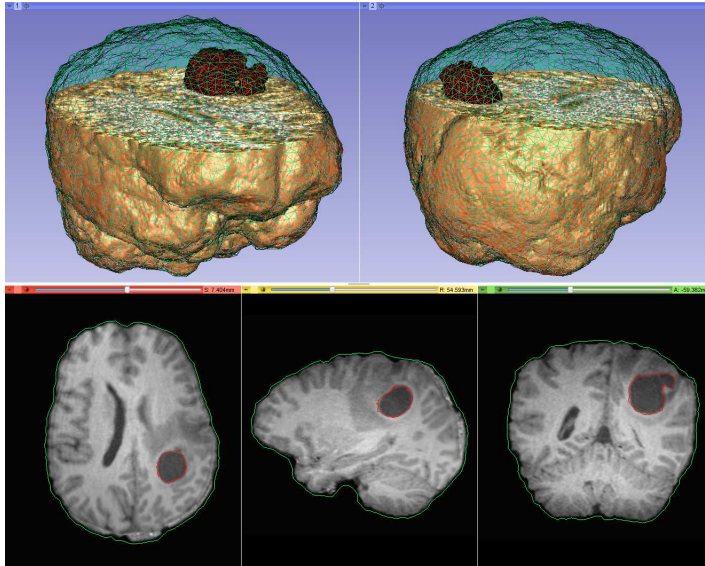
A heterogeneous brain FE biomechanical model visualized with 3D Slicer. Green and red represent the surface of the brain parenchyma and tumor sub-mesh, respectively. Top row: the generated mesh superimposed on the (cropped) volume MRI. Bottom row: axial, sagittal and coronal slice intersections between the MRI and the mesh surfaces.
